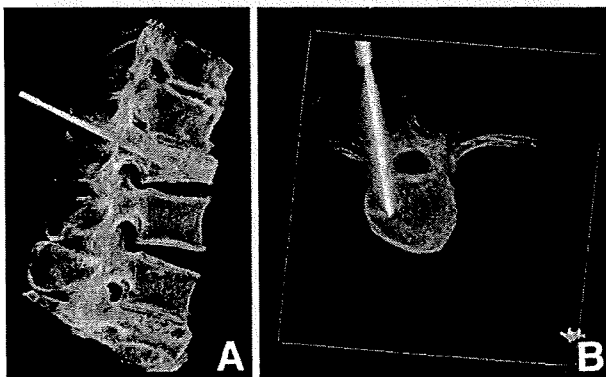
Three-dimensional radiographs after the tip of a 13-gauge needle had reached the anterior one-third of the vertebral body. A: Lateral view, B: axial view.
